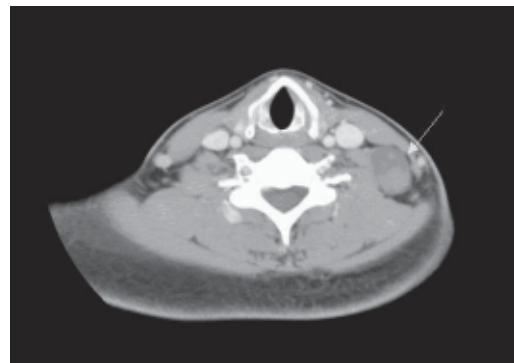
CT of patient LWY showing a 2.5-cm well-circumscribed schwannoma (arrow) in the left posterior cervical region arising from one of the upper branches of the brachial plexus. It has mild inhomogeneous internal enhancement and is closely related to the left scalenus anterior and medius muscles.
